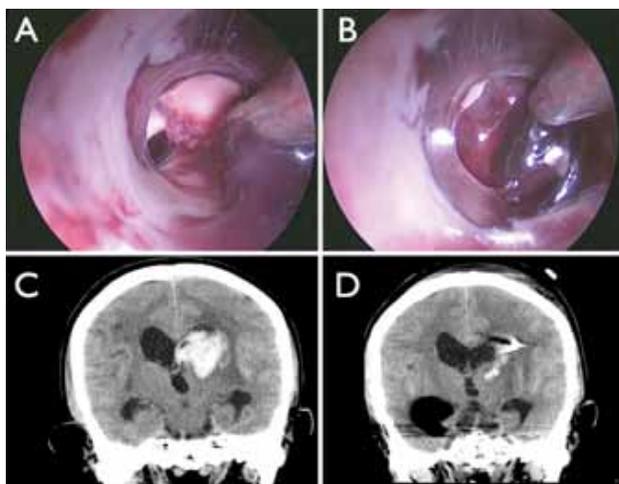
Endoscope-assisted evacuation of left thalamic ICH and IVH with acute hydrocephalus. A and B: Intraoperative images showing evacuation of the IVH (A) and ICH (B). The IVH was evacuated through the sheath inserted through the ipsilateral Kocher point (A). The ipsilateral foramen of Monro was seen after IVH evacuation. The ICH was evacuated through the rupture site on the thalamus (B). We do not enter the thalamus for more complete hematoma evacuation. C: Preoperative coronal CT scan showing the left thalamic ICH and the IVH. D: Postoperative CT scan showing some residual hematoma and the EVSD that was inserted through the operation tract.
